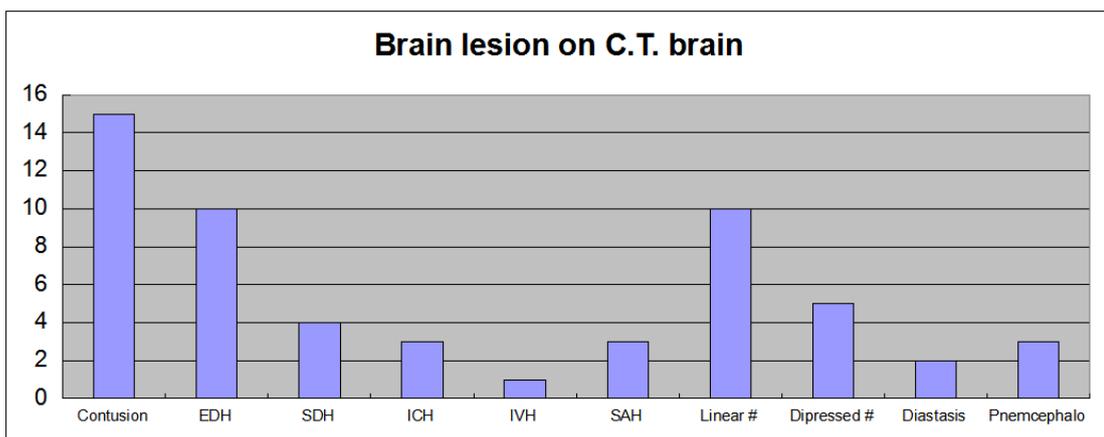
Brain lesions on CT scan
